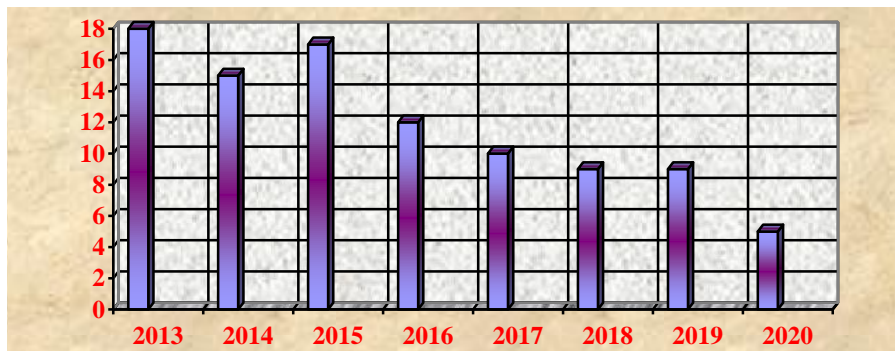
Doppler annual dynamics in all the patients with carotid endarterectomy
